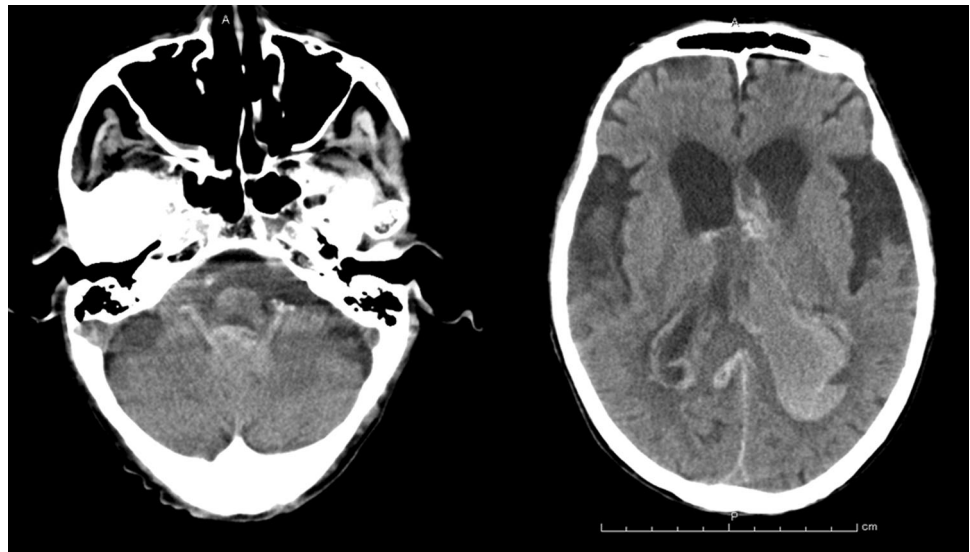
Cranial CT imaging showing an acute lesion of *left-sided* intracerebral hemorrhage that ruptured into the lateral ventricle
